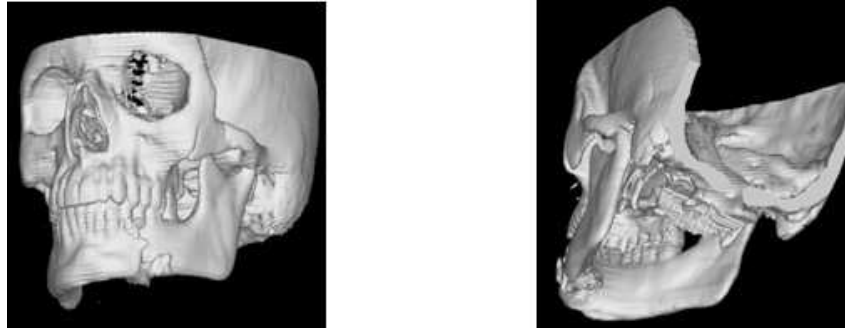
3D CT images of patient 4. Fracture comminution, extent and displacement are more clearly visible in 3D images
